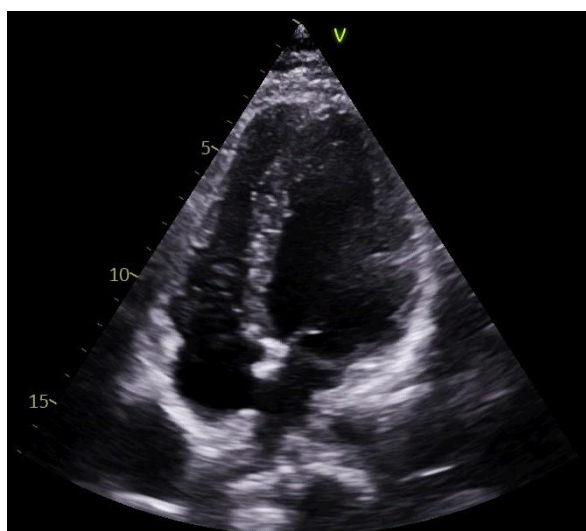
Apical four-chamber view showing Cardiomyopathy & thrombus in situ.
